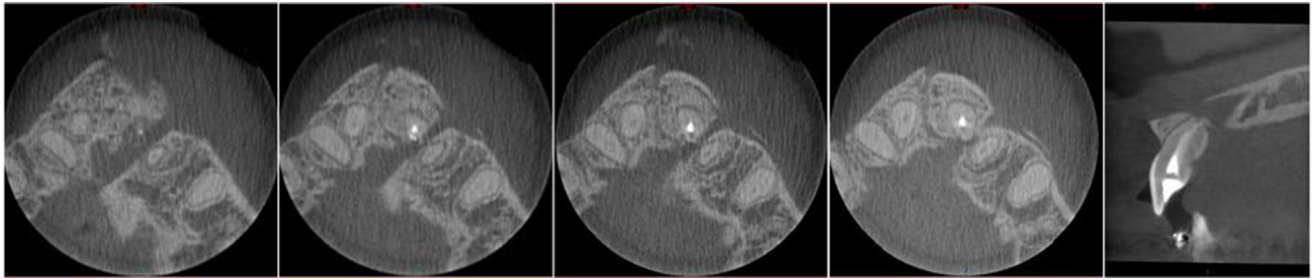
The latest CBCT radiograph showcasing a well-obturated tooth 9 with a large radiolucent lesion affecting both the palatal and buccal cortices.
